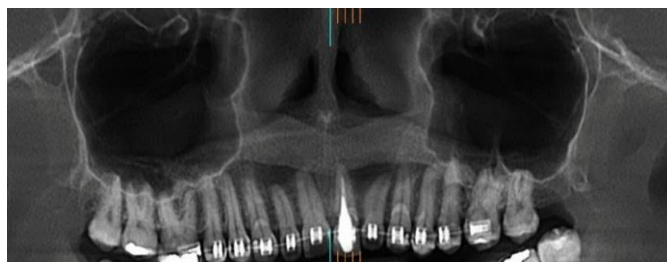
Panoramic reconstruction of the maxilla revealing a root fracture in tooth 21, obtained via cone-beam computed tomography (CBCT). Source: The authors.
